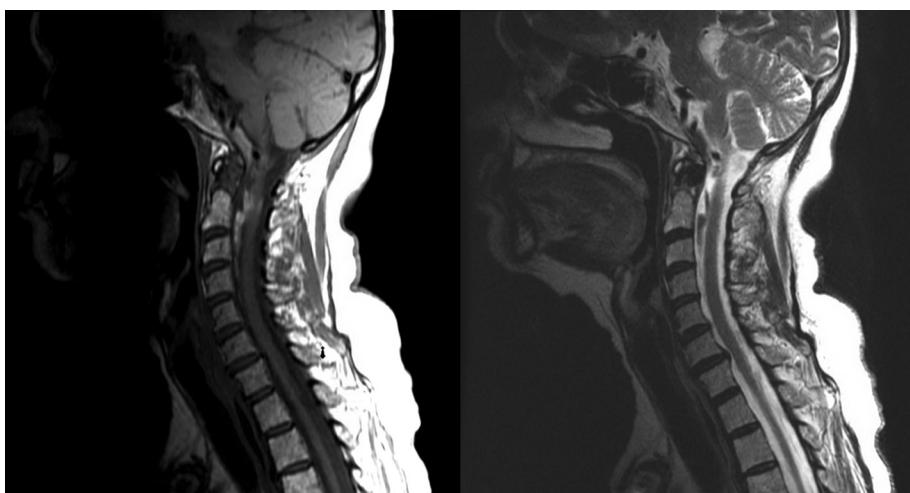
Sagittal T1-weighted (Left) and T2-weighted (Right) magnetic resonance image of the cervical spine showing presence of a ventral high cervical spinal subdural collection with signal intensity suggestive of a subacute subdural hematoma.
